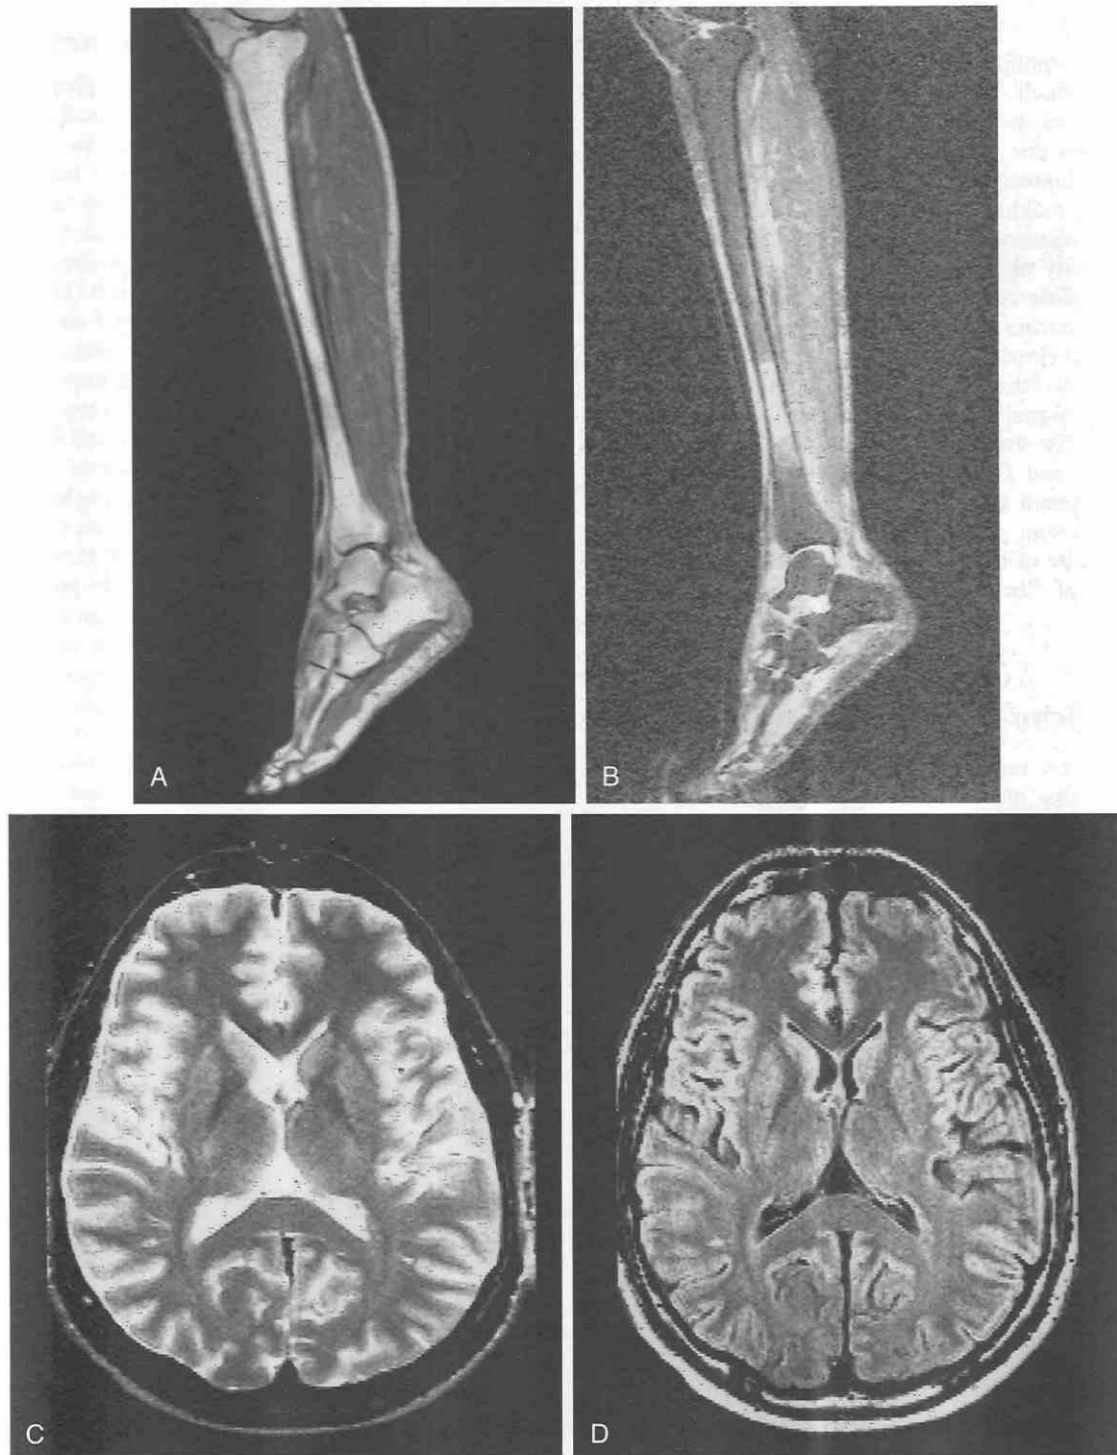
Inversion recovery sequences can be designed to generate transverse magnetization when the longitudinal magnetization has relaxed to zero following an initial inversion. *A*, Conventional T1-weighted spin echo. *B*, Conventional T1-weighted short tau inversion recovery (STIR) in which the signal from fat is removed. Note the appearance of a significant signal in the marrow once the fatty component is removed. *C*, Conventional T2-weighted spin echo. Note the high signal amplitude in the ventricles. *D*, Fluid-attenuating inversion recovery (FLAIR) acquisition in which the basic contrast between tissues in the parenchyma is unchanged from the original T2-weighted spin echo, except for the loss of the cerebrospinal fluid (CSF) signal.
